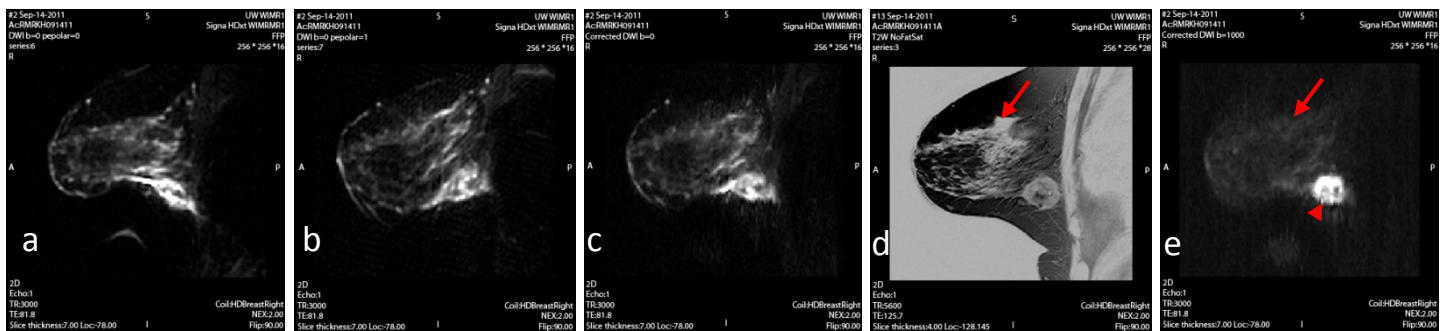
(a) b₀ DWI with PeDir pointing up, (b) b₀ DWI with PeDir point down, (c) b₀ of corrected DWI, (d) T2W No fat Suppression, shown with inverted gray scale, to be more compatible with other images in this set, (e) b=1000 of corrected DWI. Arrow pointing at glandular tissue, arrow head pointing at tumor
